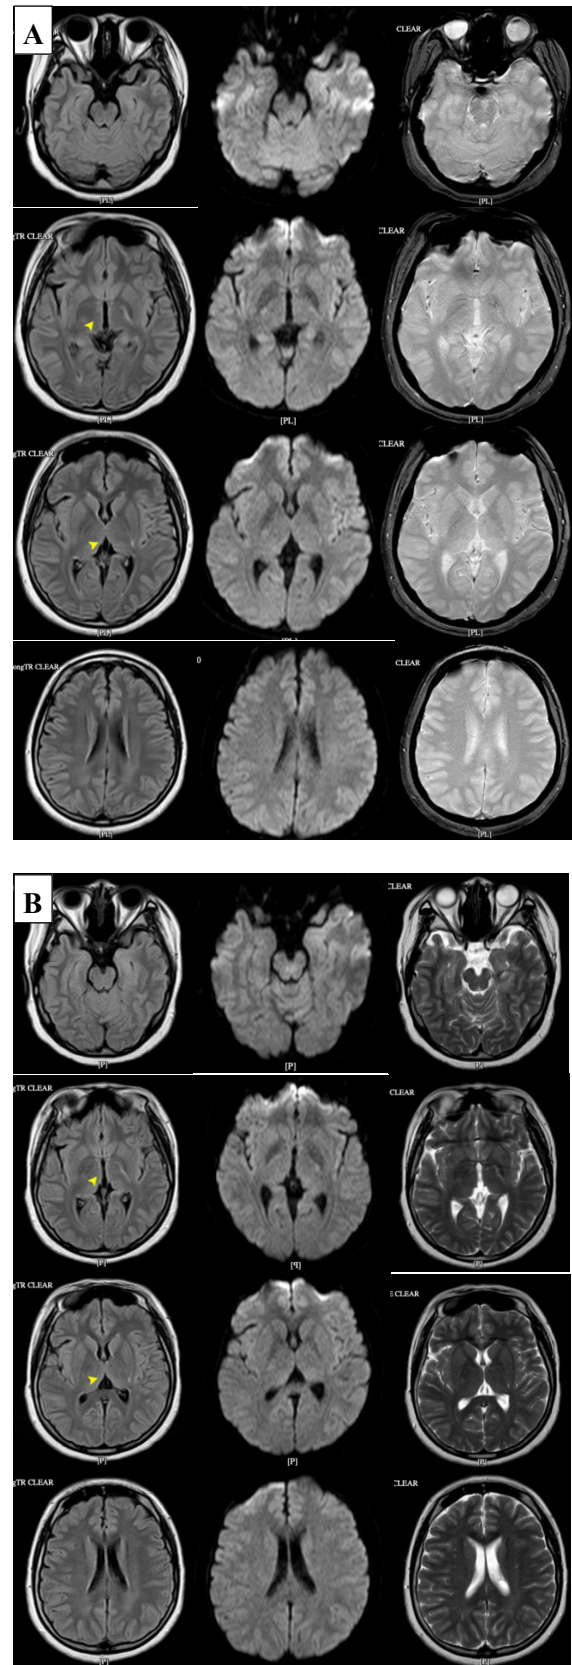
Brain MRI without contrast, performed in (A) 2023 and (B) 2022, showed pathological lesions in the posterior crus of the left internal capsule (yellow head arrow), consistent with an old infarct, while other intracranial structures were within normal limits
